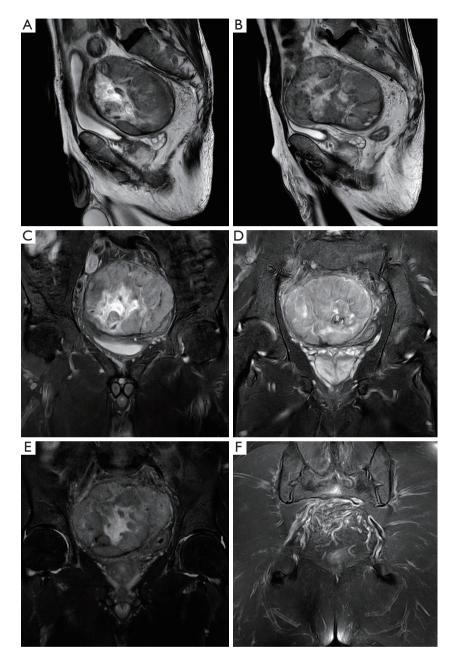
The MRI examination results of different planes and angles. (A,B) Sagittal plane MRI figure. (C-F) Different planes of pelvic posterior coronal MRI figure. MRI, magnetic resonance imaging.
